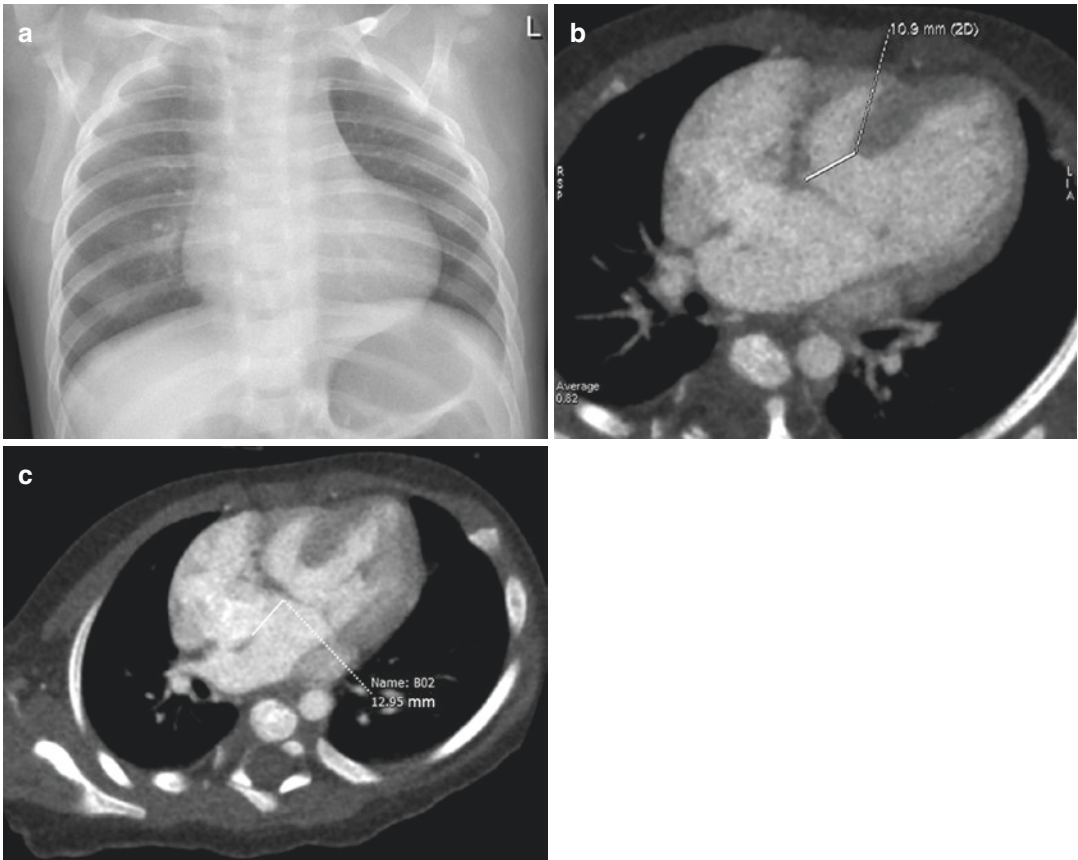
Tricuspid stenosis in an 8-month-old boy with cyanosis after birth, and cardiac murmur for 1 month. (a) Chest radiograph shows decreased blood supply to the lung fields, with pruning of hilar vessels. The cardiac silhouette is enlarged. (b and c) Contrast-enhanced CT
